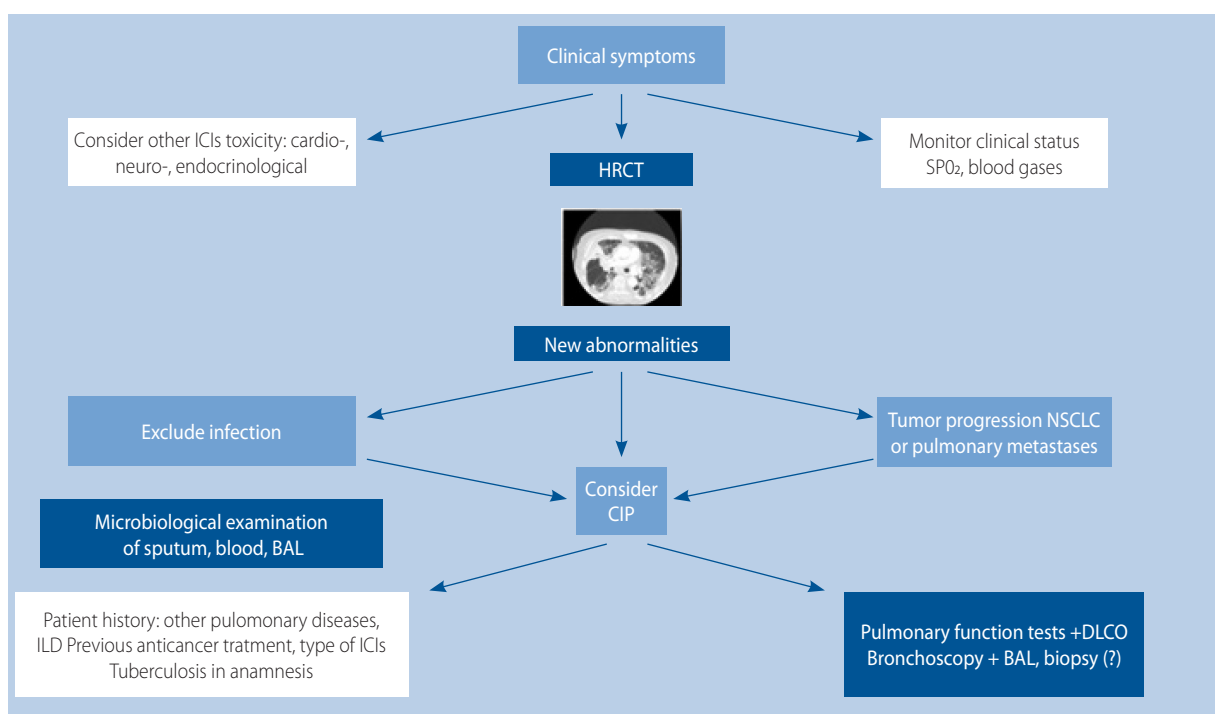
Diagnosis and differential diagnosis of checkpoint inhibitors pneumonitis (CIP). HRCT – high resolution computed tomography, BAL – bronchoalveolar lavage, SpO₂ – oxygen blood saturation, DLCO – diffusing capacity, ILD – interstitial lung disease, NSCLC – non-small-cell lung cancer
